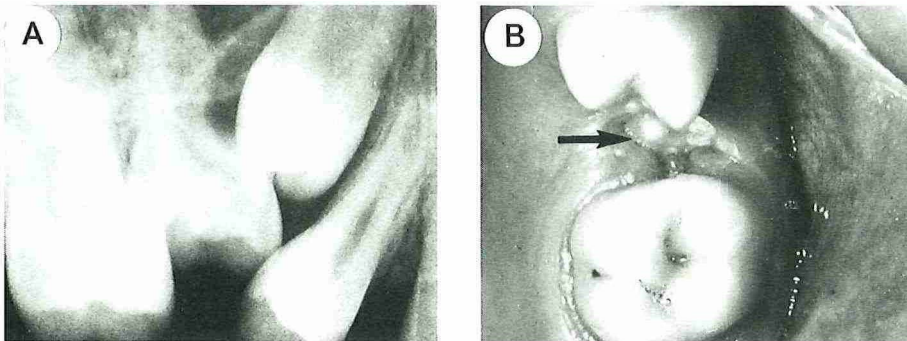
A Intra-oral periapical radiograph of a 13-year-old girl with secondary retention of the maxillary left second deciduous molar. B Clinical view of the same patient, the retained molar being covered by the surrounding tissues.(arrow)
